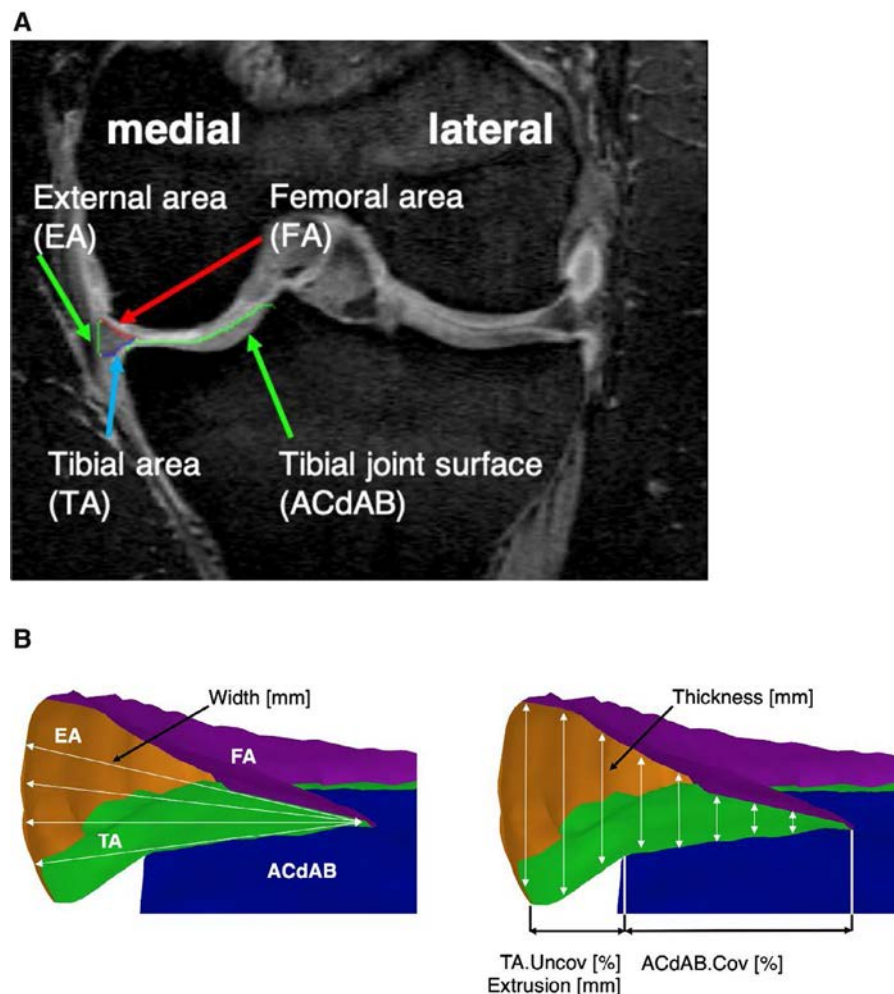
Three-dimensional (3-D) analysis of the menisci. Magnetic resonance imaging (MRI)-based, quantitative 3-D analysis of the menisci. A, Coronal MRI from a double-echo steady-state sequence with water excitation, with segmentation; B, 3-D reconstruction of the medial meniscus depicting joint surface of the tibia, consisting of 1) the area of the cartilage surface and denuded areas of subchondral bone (ACdAB), if applicable; 2) the femoral, tibial, and external surface of the medial meniscus; 3) meniscal thickness and width; 4) overlap between the tibial area (TA) and ACdAB (ACdAB.Cov [%]), uncovered area of the TA (TA.Uncov [%]), and 5) extrusion distance. The mean parameters represent the average, the maximum parameters the greatest value across all slices.
